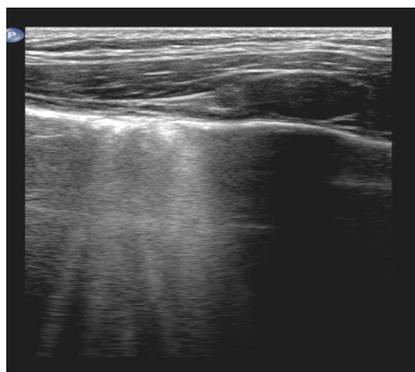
Lung ultrasound of a patient with dilated cardiomyopathy and pulmonary oedema. One field of view shows at least 3 B-lines, spreading throughout the lung, while the distance between them is decreased to 3 mm, or they fuse together.
